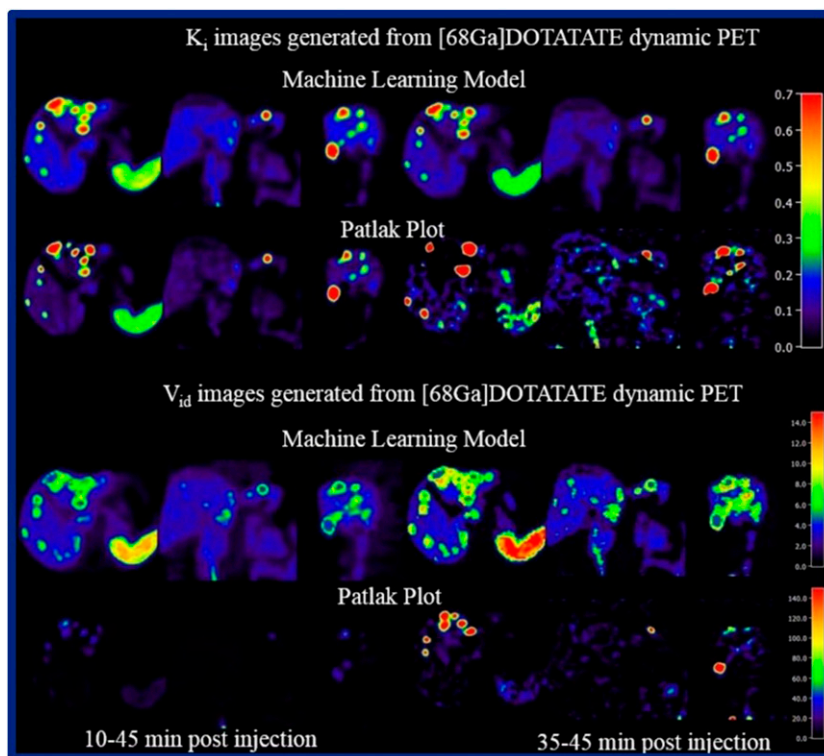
A machine learning-based parametric imaging algorithm for noninvasive quantification of dynamic ^{68}Ga -DOTATATE PET/CT. Top block: K_i images generated from ^{68}Ga -DOTATATE dynamic PET using: (top row) a machine learning model and (bottom row) Patlak plots. Bottom block: V_{id} images generated from ^{68}Ga -DOTATATE dynamic PET using: (top row) a machine learning model and (bottom row) Patlak plots.
